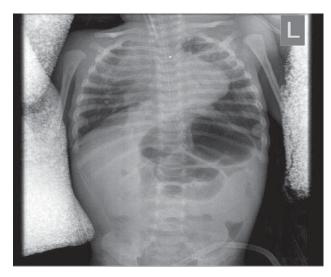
X-ray of a lung: left-sided pneumonia
